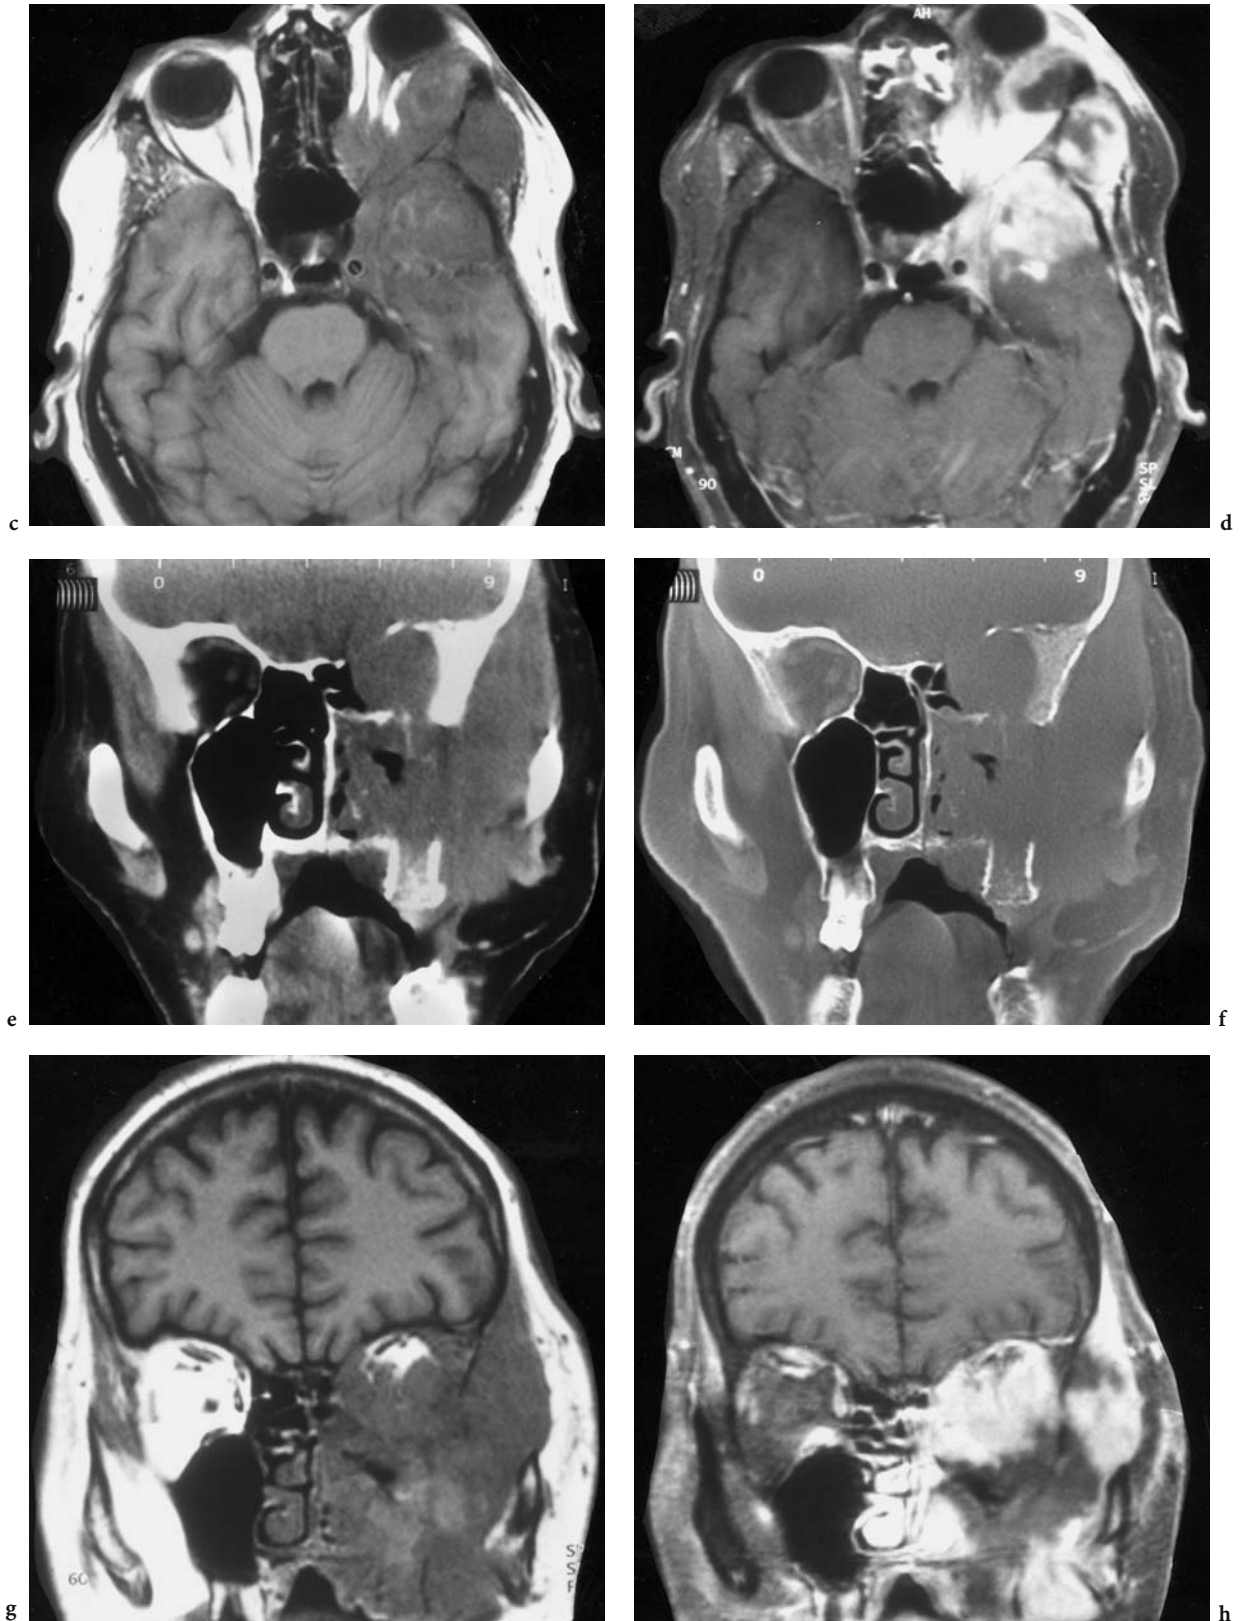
A 44-year-old man after complete therapy for a T-cell lymphoma (chemotherapy and radiation), presenting with swollen and protruding left eye and suspected osteomyelitis of the upper jawbone. Diagnosis: T-cell lymphoma. a Axial CT of the upper orbital region where an intra- and extraorbital, intra- and extracranial mass is seen. b Corresponding T2-weighted MRI, demonstrating not only the extreme proptosis caused by the mass, but also a temporopolar mass with perifocal edema...
